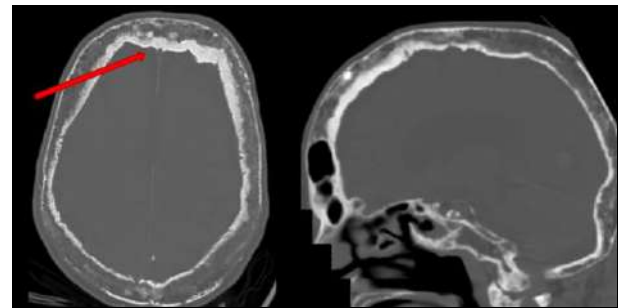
CT brain –bone window shows mixed lytic sclerotic changes with widened diploic space & coarse trabeculae involving calvarium fully giving a cotton wool appearance
